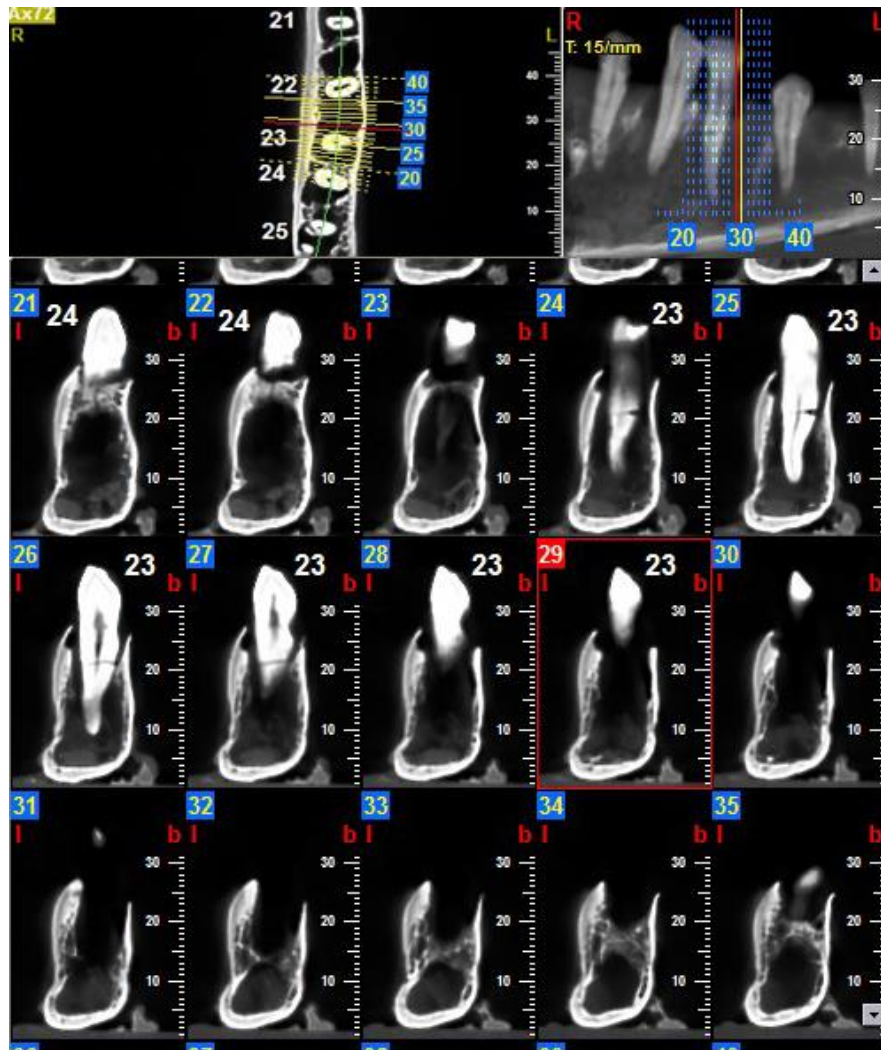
CBCT images of broken teeth
